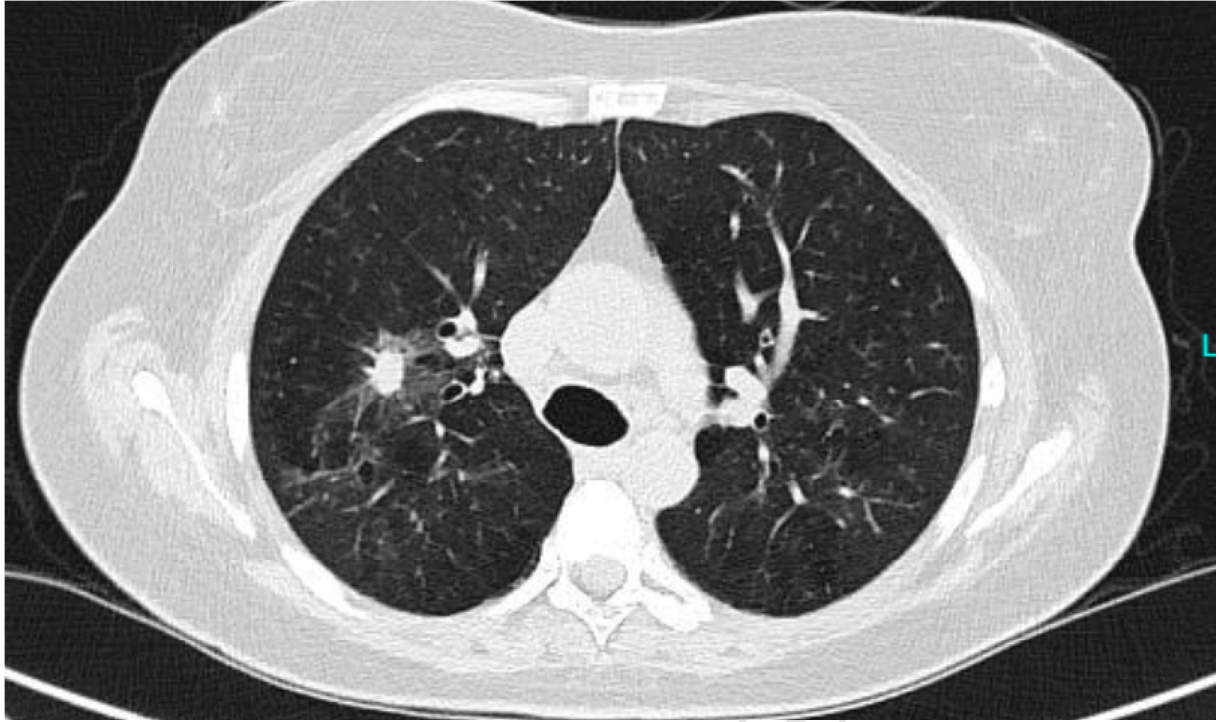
Chest computed tomography.
